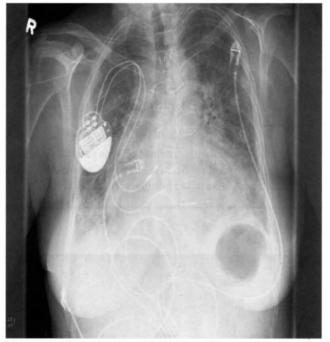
This chest x-ray has been taken at the emergency department. Note the florid pulmonary edema, cardiomegaly, wires from previous sternotomy, dual chamber pacemaker.
